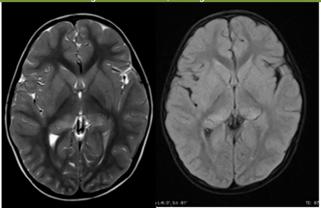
T2 Axial a) and FLAIR axial, b) depicting bilateral symmetrical thalamic involvement.
